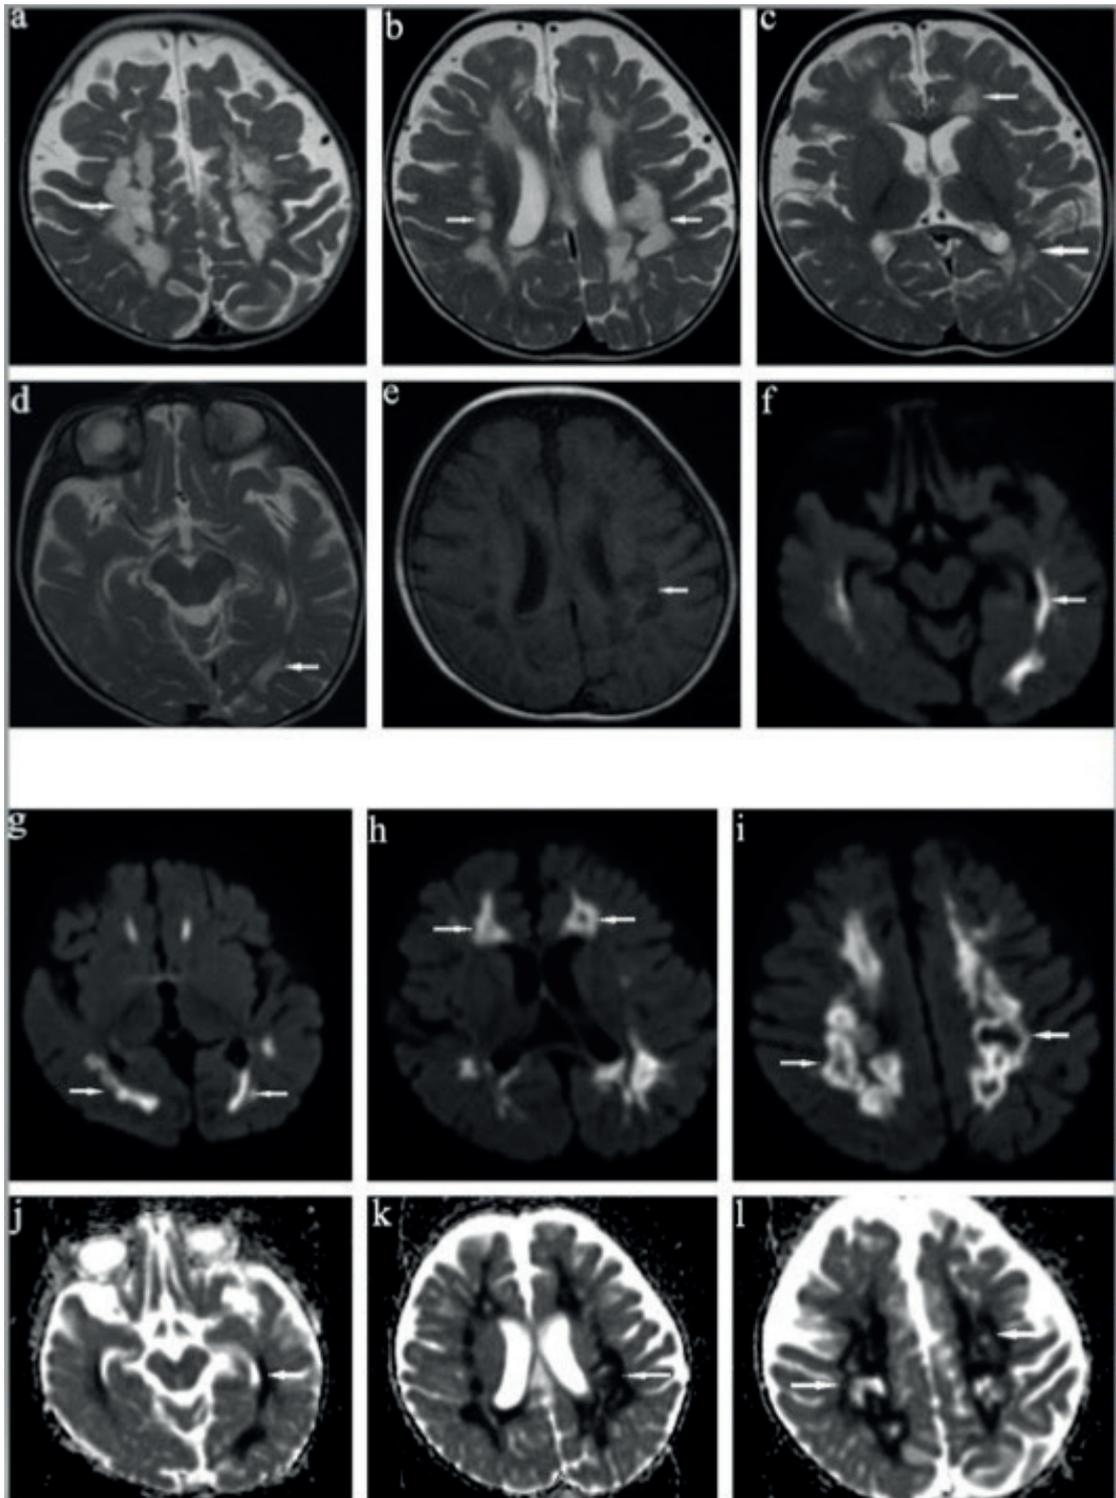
There are extensive, symmetrical periventricular and deep cerebral white matter abnormalities with sparing of the U fibers of the cerebral hemispheres. The internal capsule, corticospinal tracts in the brain stem and the cerebellar white matter are normal (a,b,c,d). The T1-weighted images reveal that the involvement has an abnormally low signal intensity and cystic nature (e). Also, there are extensive signal abnormalities that refer to abnormal restricted diffusion in the diffusion-weighted imaging (f, g, h, i, j, k, l).
